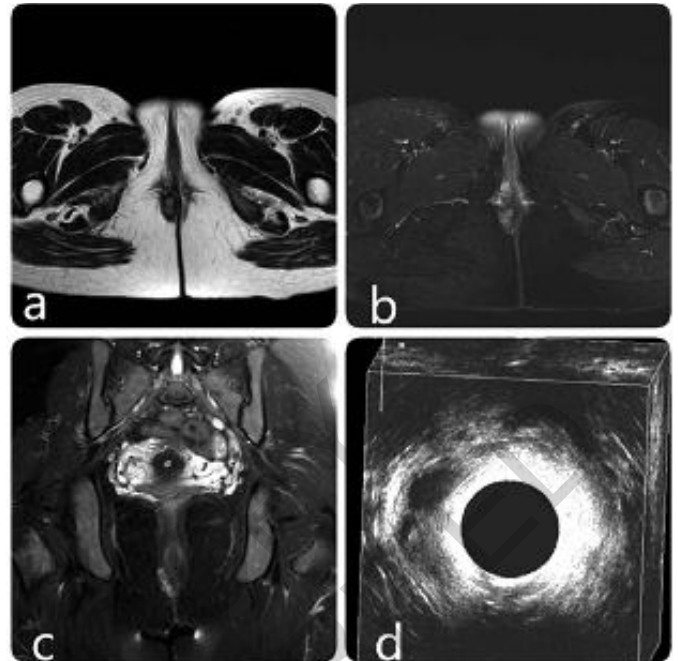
A) Hypointense heterogeneous, well-circumscribed nodular lesion on the right lateral perineal midline on axial T1-weighted MRI; B) Increased enhancement in the center of the lesion on T1-weighted MRI with axial fat suppression; C) Contrast-enhanced T1-weighted MRI with coronal fat suppression showed contrast enhancement in the lesion; D) Hypoechoic nodular lesion involving the external anal sphincter on 3-dimensional endoanal ultrasonographic examination.
